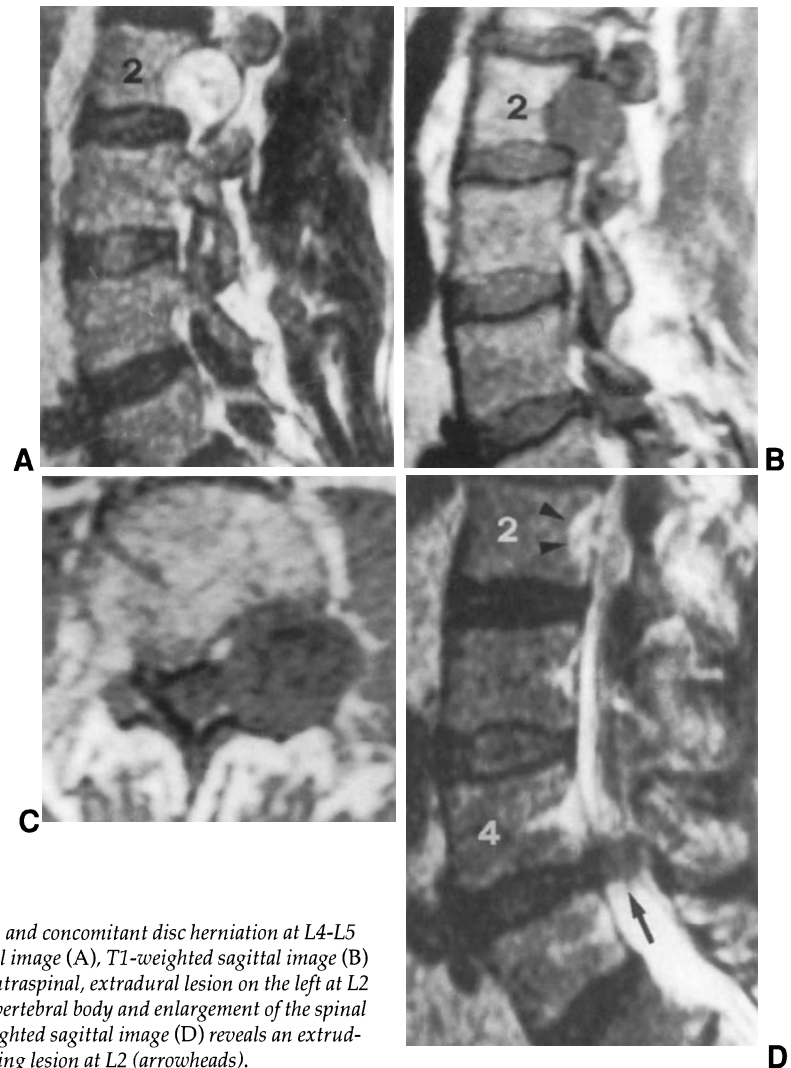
MR images of a patient with neurinoma at L2 and concomitant disc herniation at L4-L5 level, on the left side. The spin-echo T2-weighted sagittal image (A), T1-weighted sagittal image (B) and T1-weighted axial image (C) show an expanding, intraspinal, extradural lesion on the left at L2 level, which causes erosion of the posterior aspect of L2 vertebral body and enlargement of the spinal canal and intervertebral foramen. The spin-echo T2-weighted sagittal image (D) reveals an extruded disc herniation at L4-L5 level (arrow) and an expanding lesion at L2 (arrowheads).
